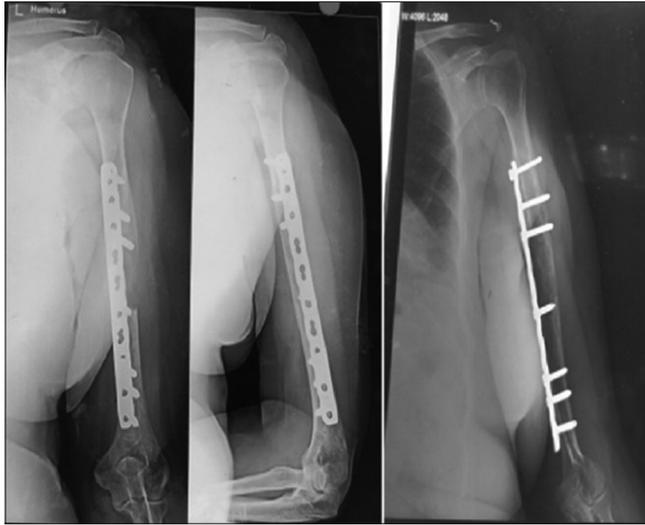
Radiographs showing pathological fracture of the left humerus and fixation done for the same
